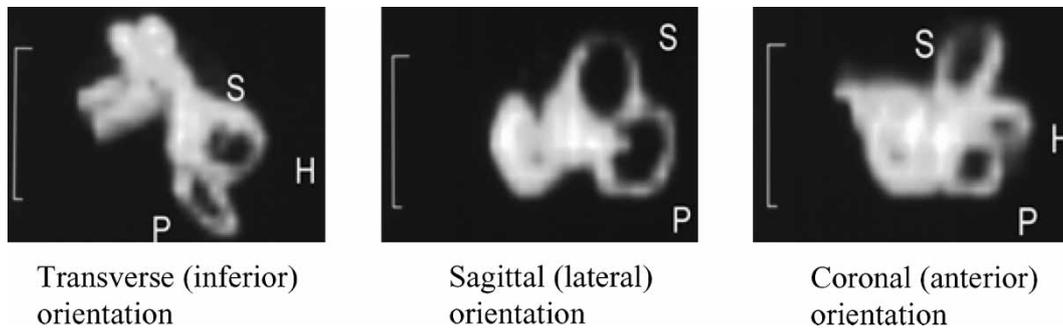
Anatomical definitions and views in the three different planes. HR-3D-MRI reconstructions of a normal left inner ear. S = superior semicircular canal (anterior); H = horizontal semicircular canal (lateral); P = posterior semicircular canal.
